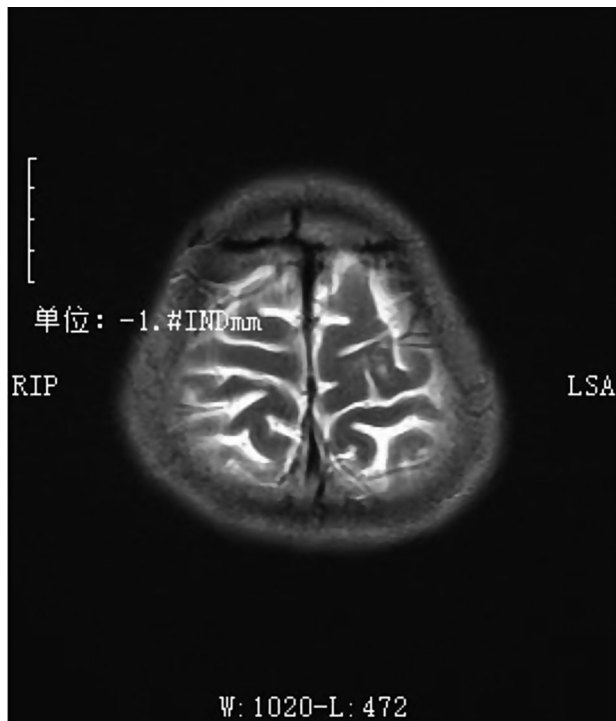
Head MRI after treatments. Head MRI shows a significant reduction in edema surrounding the lesion in the left frontal lobe compared to before
